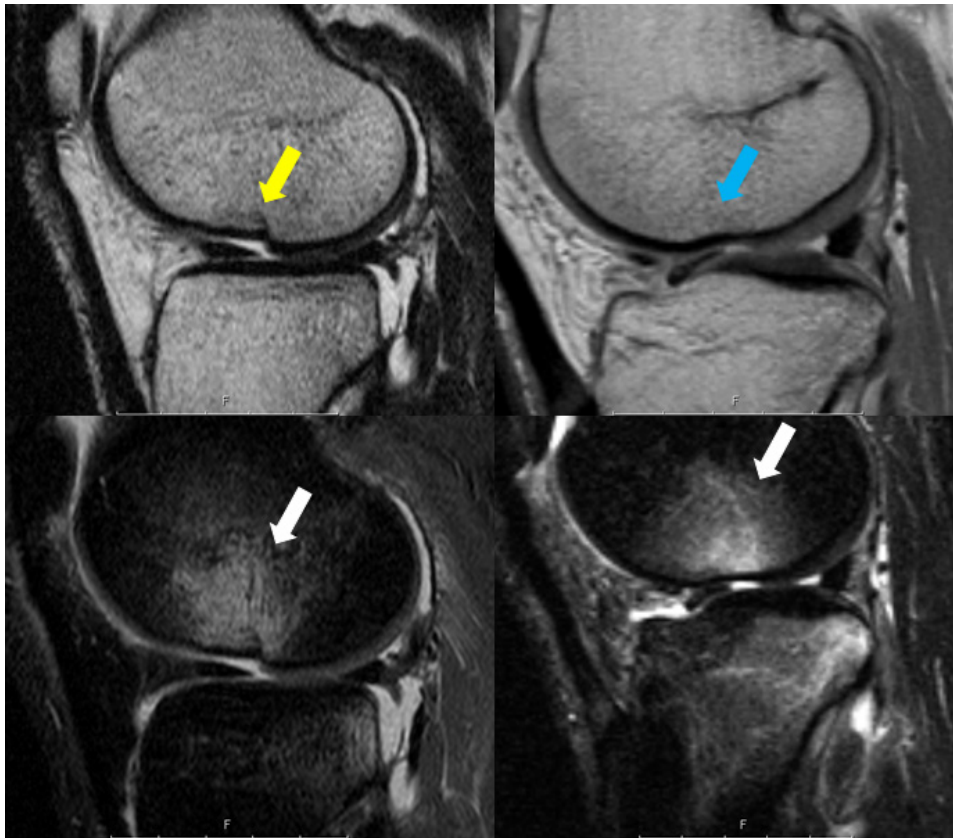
Magnetic resonance images of knees used in Study IV. Upper row: proton density T2-weighted sequence and bottom row: short-tau inversion recovery (STIR) sequence of knees with osteochondral fractures with disrupted cortical bone in the femur (yellow arrow) and without disrupted cortical bone in the femur (blue arrow). The STIR sequence images (bottom row) clearly show the surrounding post-traumatic bone marrow lesion of the osteochondral fracture above, indicating traumatic impact forces (white arrows).
